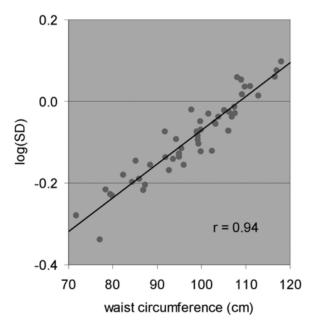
For 50 consecutive persons undergoing CT colonography, the waist circumference was measured, and the mean standard deviation (*SD*) at the colon surface. The waist circumference is on the *horizontal axis*, the logarithm of the SD on the *vertical axis*. The level of the SD is taken to be arbitrary. Higher SD values correspond with a lower image quality. The logarithm of the SD is approximately linearly related to the waist circumference. At 120 cm waist circumference the mean SD is 2.6 times higher than at 70 cm
